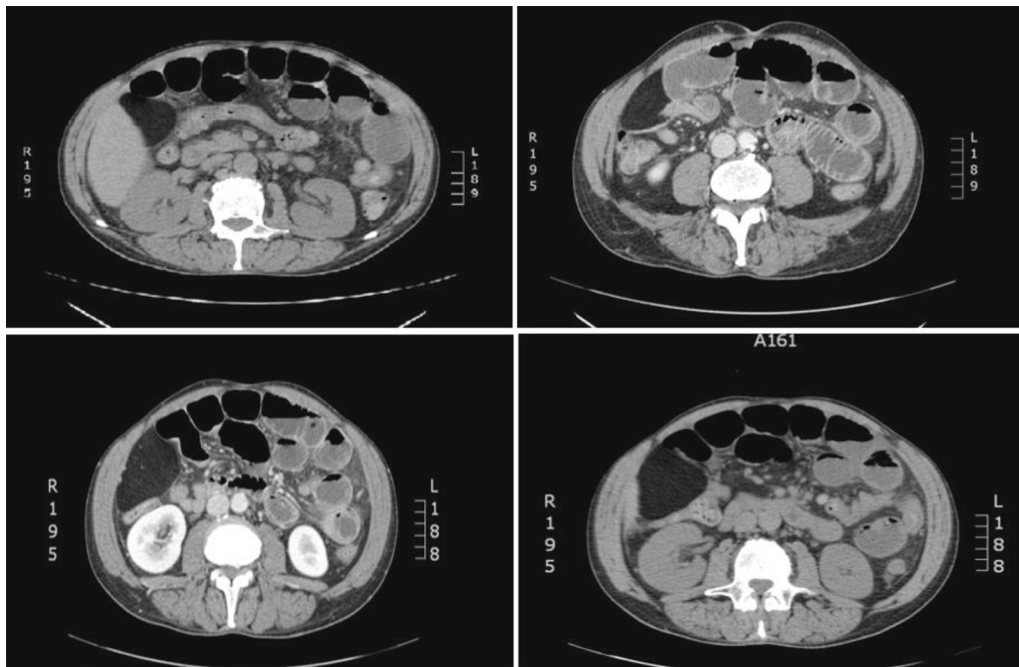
Contrast-enhanced CT abdominal scan showed a dilated intestine with some air–fluid interfaces and ileal lipomatous mass involving the transition loop.
